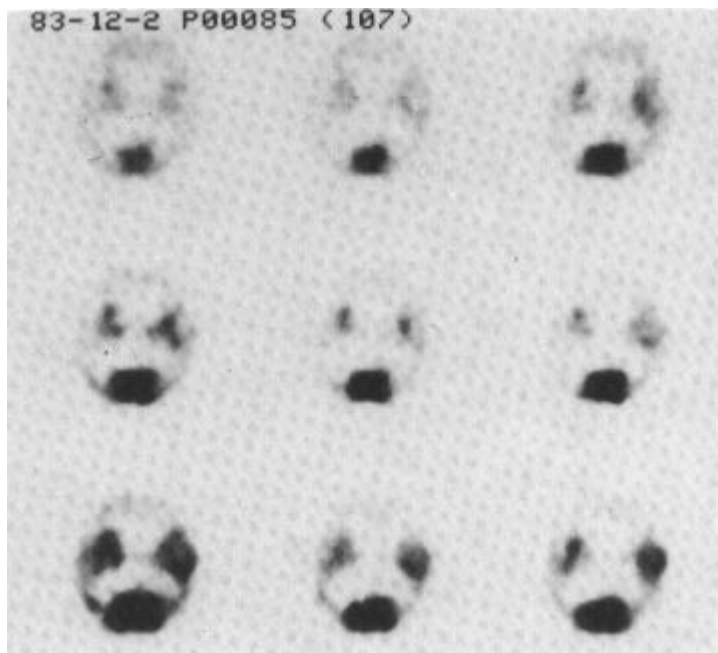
(a) Sequential images of ^{18}F FDG distribution in Alzheimer's disease
